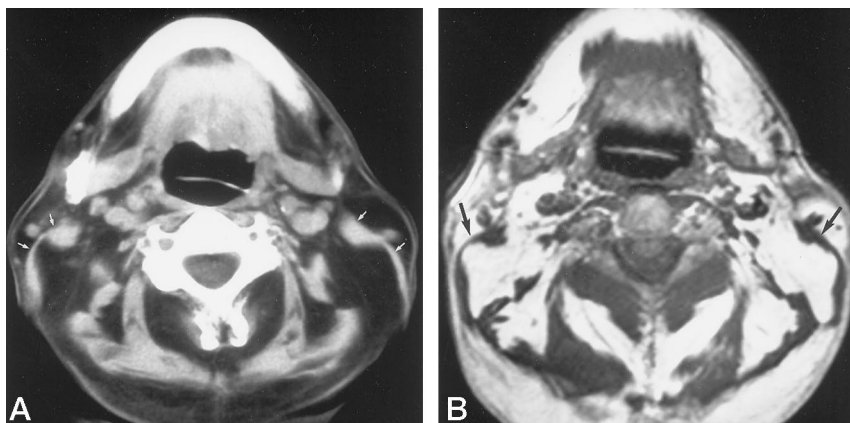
Axial noncontrast CT scan (A) and T1-weighted MR image (500/20) (B) show a thin sternomastoid muscle (arrows) with excess fat posteriorly. Also note the paraspinal distribution of the fat.
